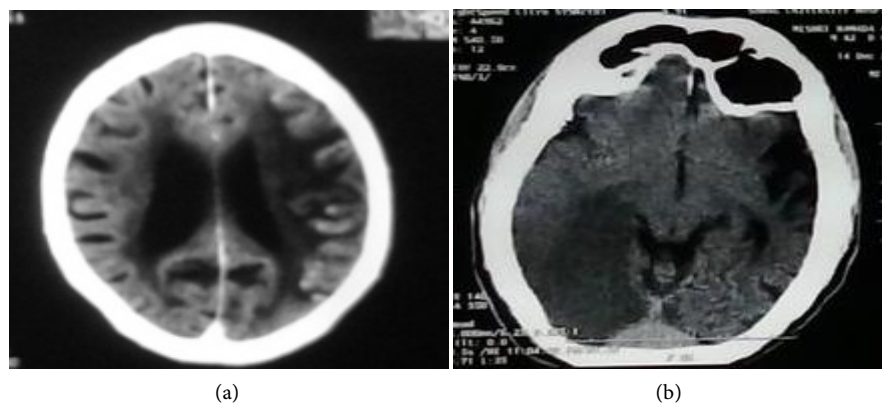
CT findings. (a) Lt cerebral infarction 1.6 \times 2.4 cm; (b) Rt occipital infarction 5 \times 4.5 cm.
